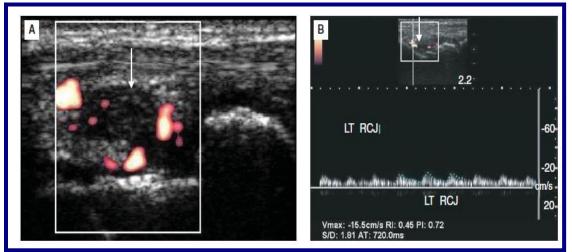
Longitudinal image of the radio-carpal joint on power Doppler showing moderately increased synovial vascularity (image A, white arrow). B Spectral Doppler tracing showing low resistance flow (RI-0.45) suggestive of active inflammation. (6)
